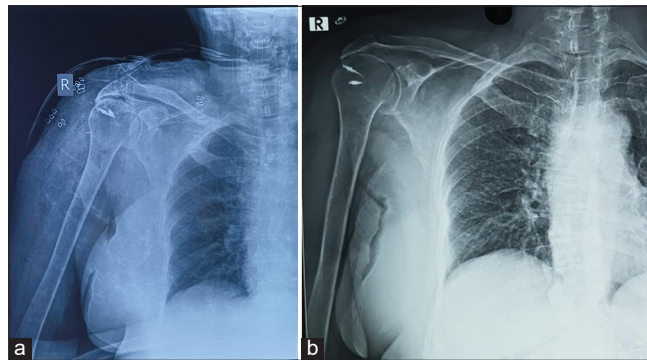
(a) Postoperative X-ray (2 weeks), (b) Postoperative X-ray after 6 months showing no loosening or anchor migration.
